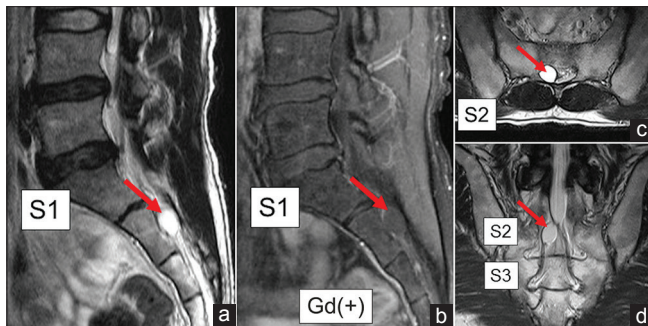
Lumbosacral magnetic resonance images. Sagittal (a and b), axial (c), and coronal (d) view of lumbosacral magnetic resonance imaging showing the cyst (red arrow) at the S2 vertebra. Preoperative magnetic resonance images showing a less-enhanced tumor (b). The contents of the cyst have the same intensity as the cerebrospinal fluid on both T2-weighted images
